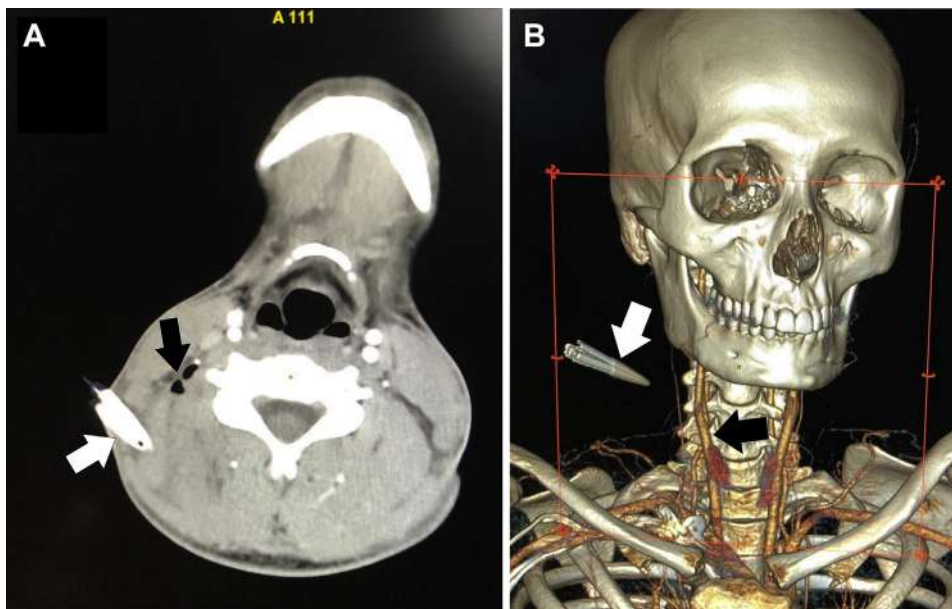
(A) An axial computed tomography angiogram image revealing a hypodense structure (white arrow) measuring 3 × 1 cm, representing the retained beak of the needlefish penetrating beyond the deep cervical fascia with the presence of air (black arrow). (B) A 3D reconstruction revealing the elongated foreign body (white arrow) 6 cm from the carotid vessels (black arrow).
